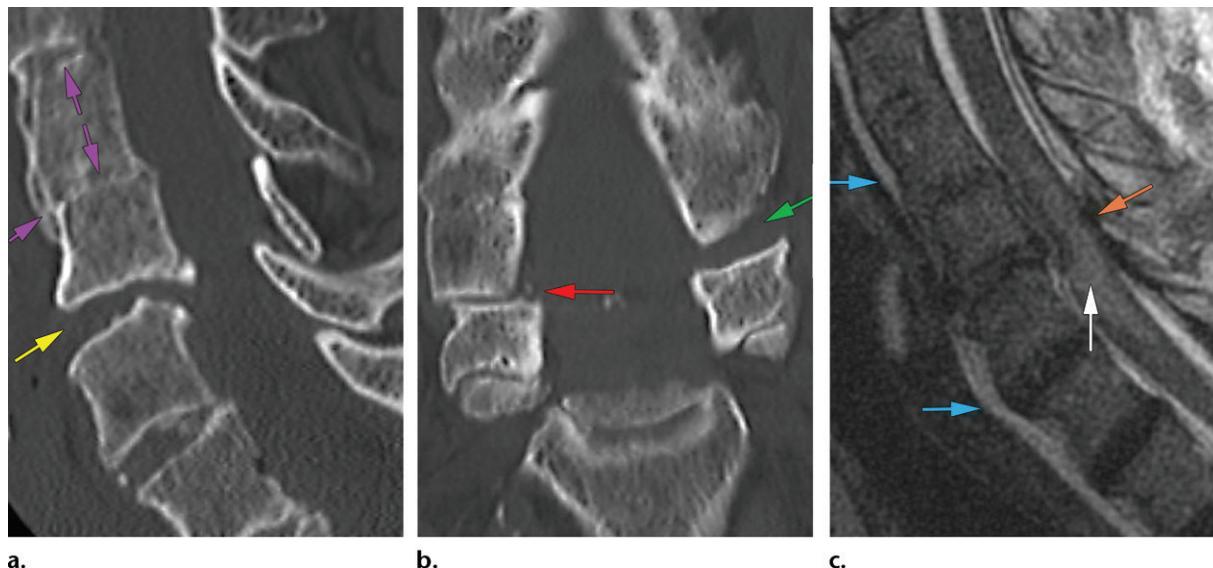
Unstable injury in an 85-year-old woman with DS who presented after a fall from standing. (a) Sagittal CT image shows degenerative osseous bridging of the cervical spine (purple arrows) and a C5-C6 hyperextension injury (yellow arrow) next to the fused segment. (b) Coronal CT image shows a fracture-translation injury of the right C5 facet (red arrow) and widening of the contralateral C5-C6 facet joint (green arrow). (c) Sagittal T2-weighted MR image shows severe canal narrowing (orange arrow), cord edema (white arrow), rupture of the ALL, and prevertebral soft-tissue edema (blue arrows).
